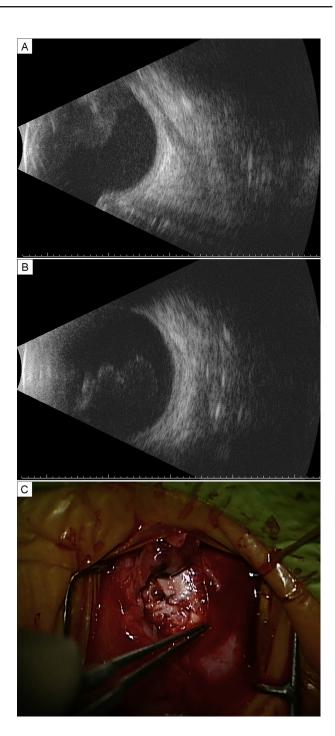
A 6-year-old boy who underwent strabismus surgery was diagnosed with endophthalmitis 13 days postoperatively and found to have full thickness scleral perforation and scleral abscess with dehiscence. A, B-scan ultrasound, longitudinal view, showing anterior vitreal opacities and optic disk elevation. B, B-scan ultrasound, superior transverse view, showing numerous vitreal opacities. C, Dehiscence of the sclera where the Vicryl (Ethicon Inc, Somerville, NJ) suture had been placed for the right superior rectus recession, with an adjacent abscess.
